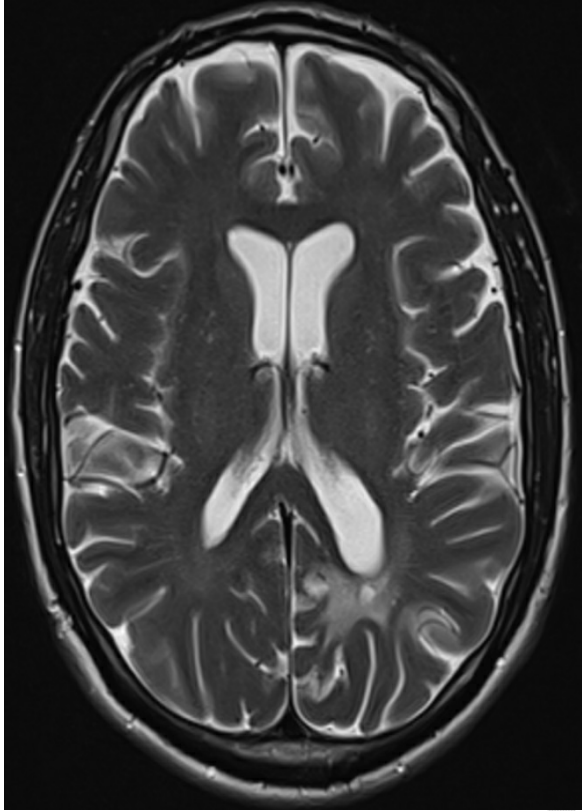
MRI of the brain, 2022
